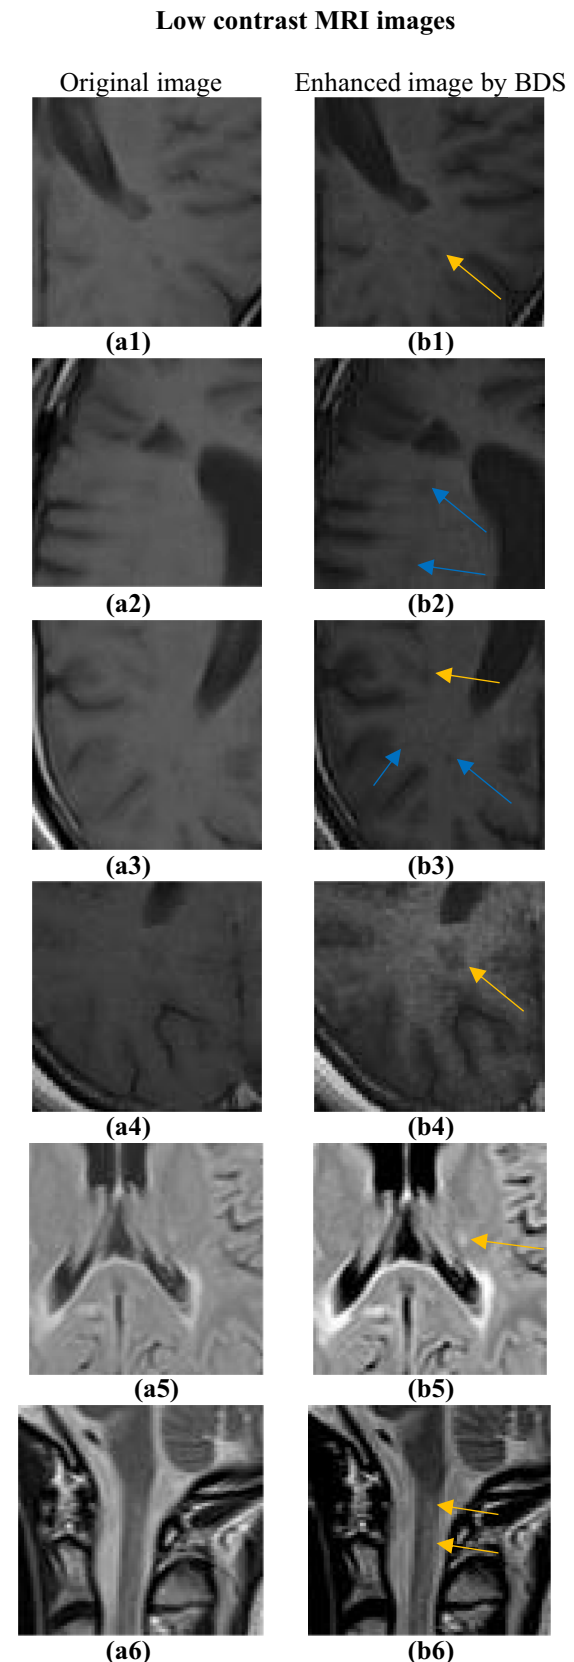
Original and enhanced images with the proposed method BDS; a1–a6 original low contrast MRI images and b1–b6 enhanced images by BDS with yellow and blue arrows representing MS lesions
